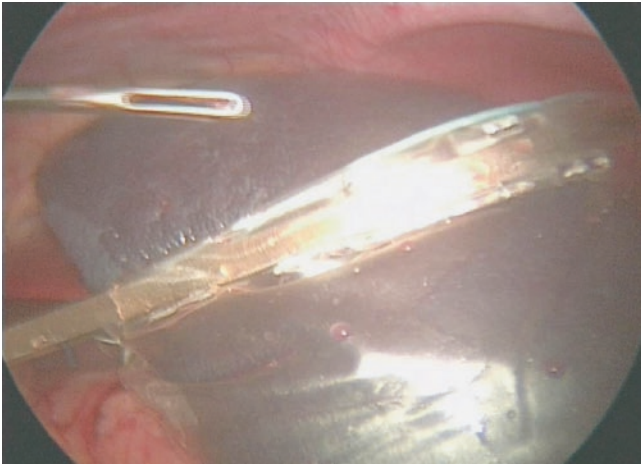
Division of splenic vein. The splenic vein can be sealed and divided again ideally with a two-step approach using either clips or a ligature, then electrothermal fusion, ultrasonic device, or a stapler using a vascular load
